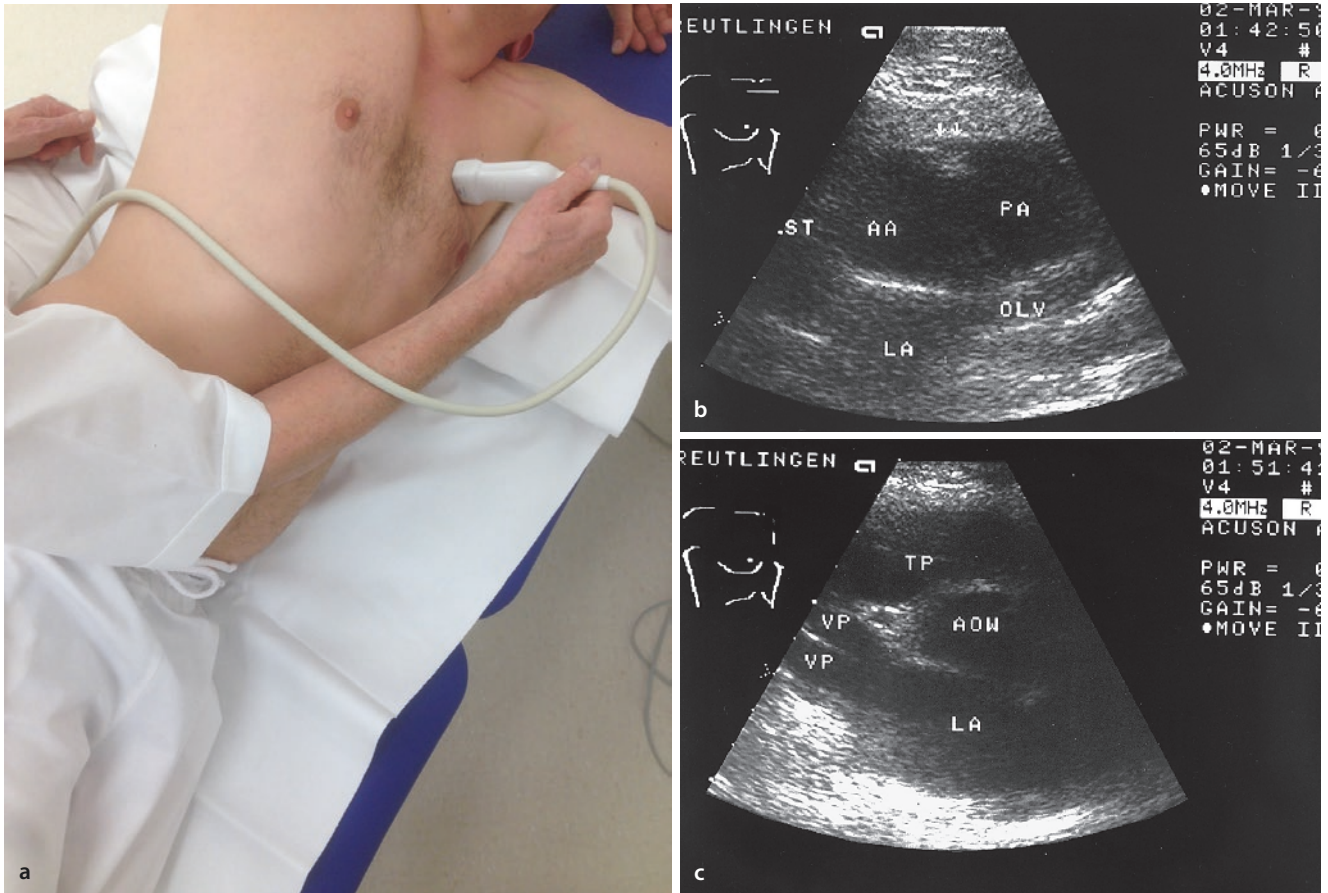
a Parasternal examination in the left lateral position. b Left parasternal, transversal section. The pulmonary artery (PA) winds around the cross-sectional ascending aorta (AA). In-between is the upper pericardial recess (double arrow), sternum (ST), left atrium (LA)
